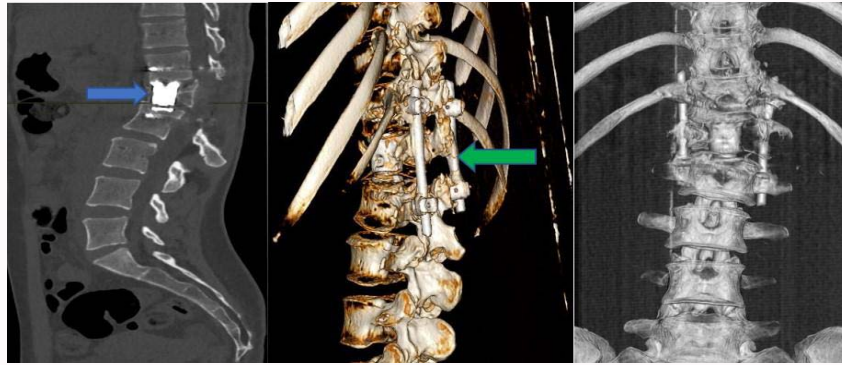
Postoperative CT scan sagittal cut and CT 3D reconstruction showing the interbody prosthesis (blue arrow) and the posterior Transpedicular fixation (green arrow). It should be noted that the 12th rib was not sacrificed intraoperatively.
